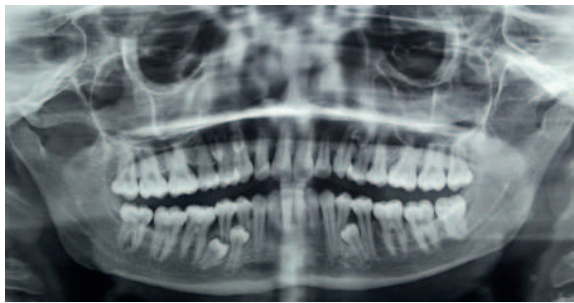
Orthopantomogram view
